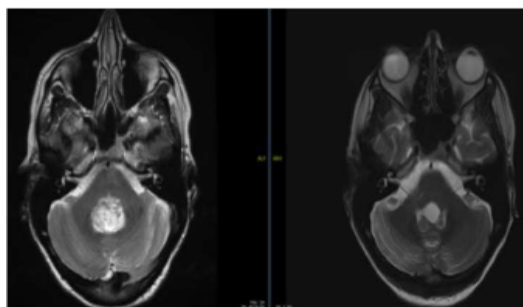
T2-weighted axial MR-images showing tumor in 4th ventricle (left) and after resection (right).
